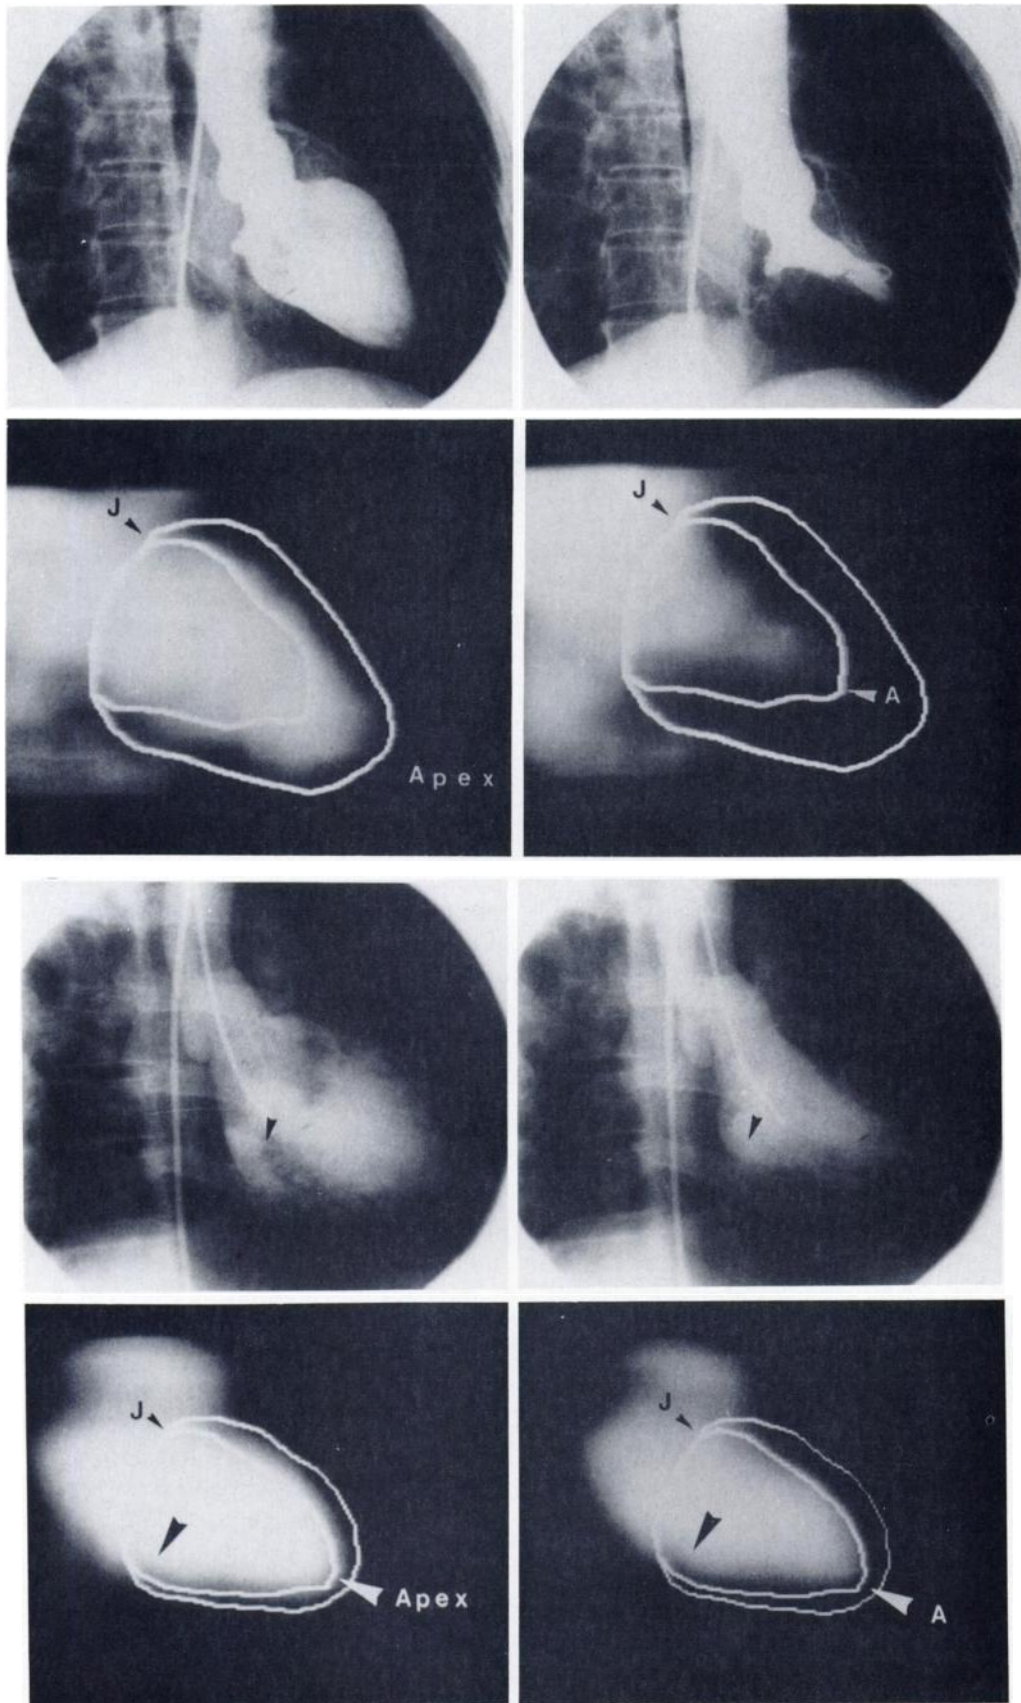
gives examples of images for patients showing normal and abnormal ventricular function, obtained from CLV and GSPECT.
